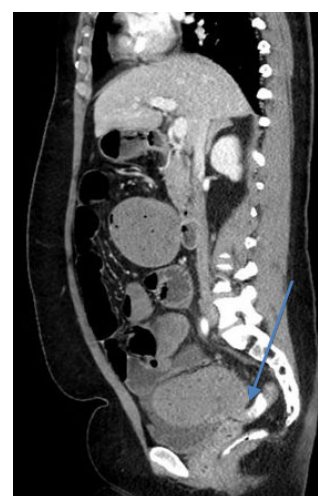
Repeat computed tomography scan with intravenous and rectal contrast on day 3 of admission showing an irregular thickened 4 cm segment of large bowel (as indicated by the arrow). This appeared to be strictureing the lumen and preventing progression of the rectal contrast proximally which gives concern for large bowel obstruction.
